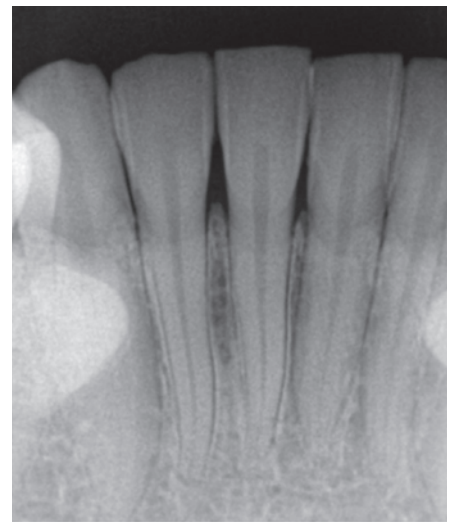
Lower central intraoral periapical radiograph
